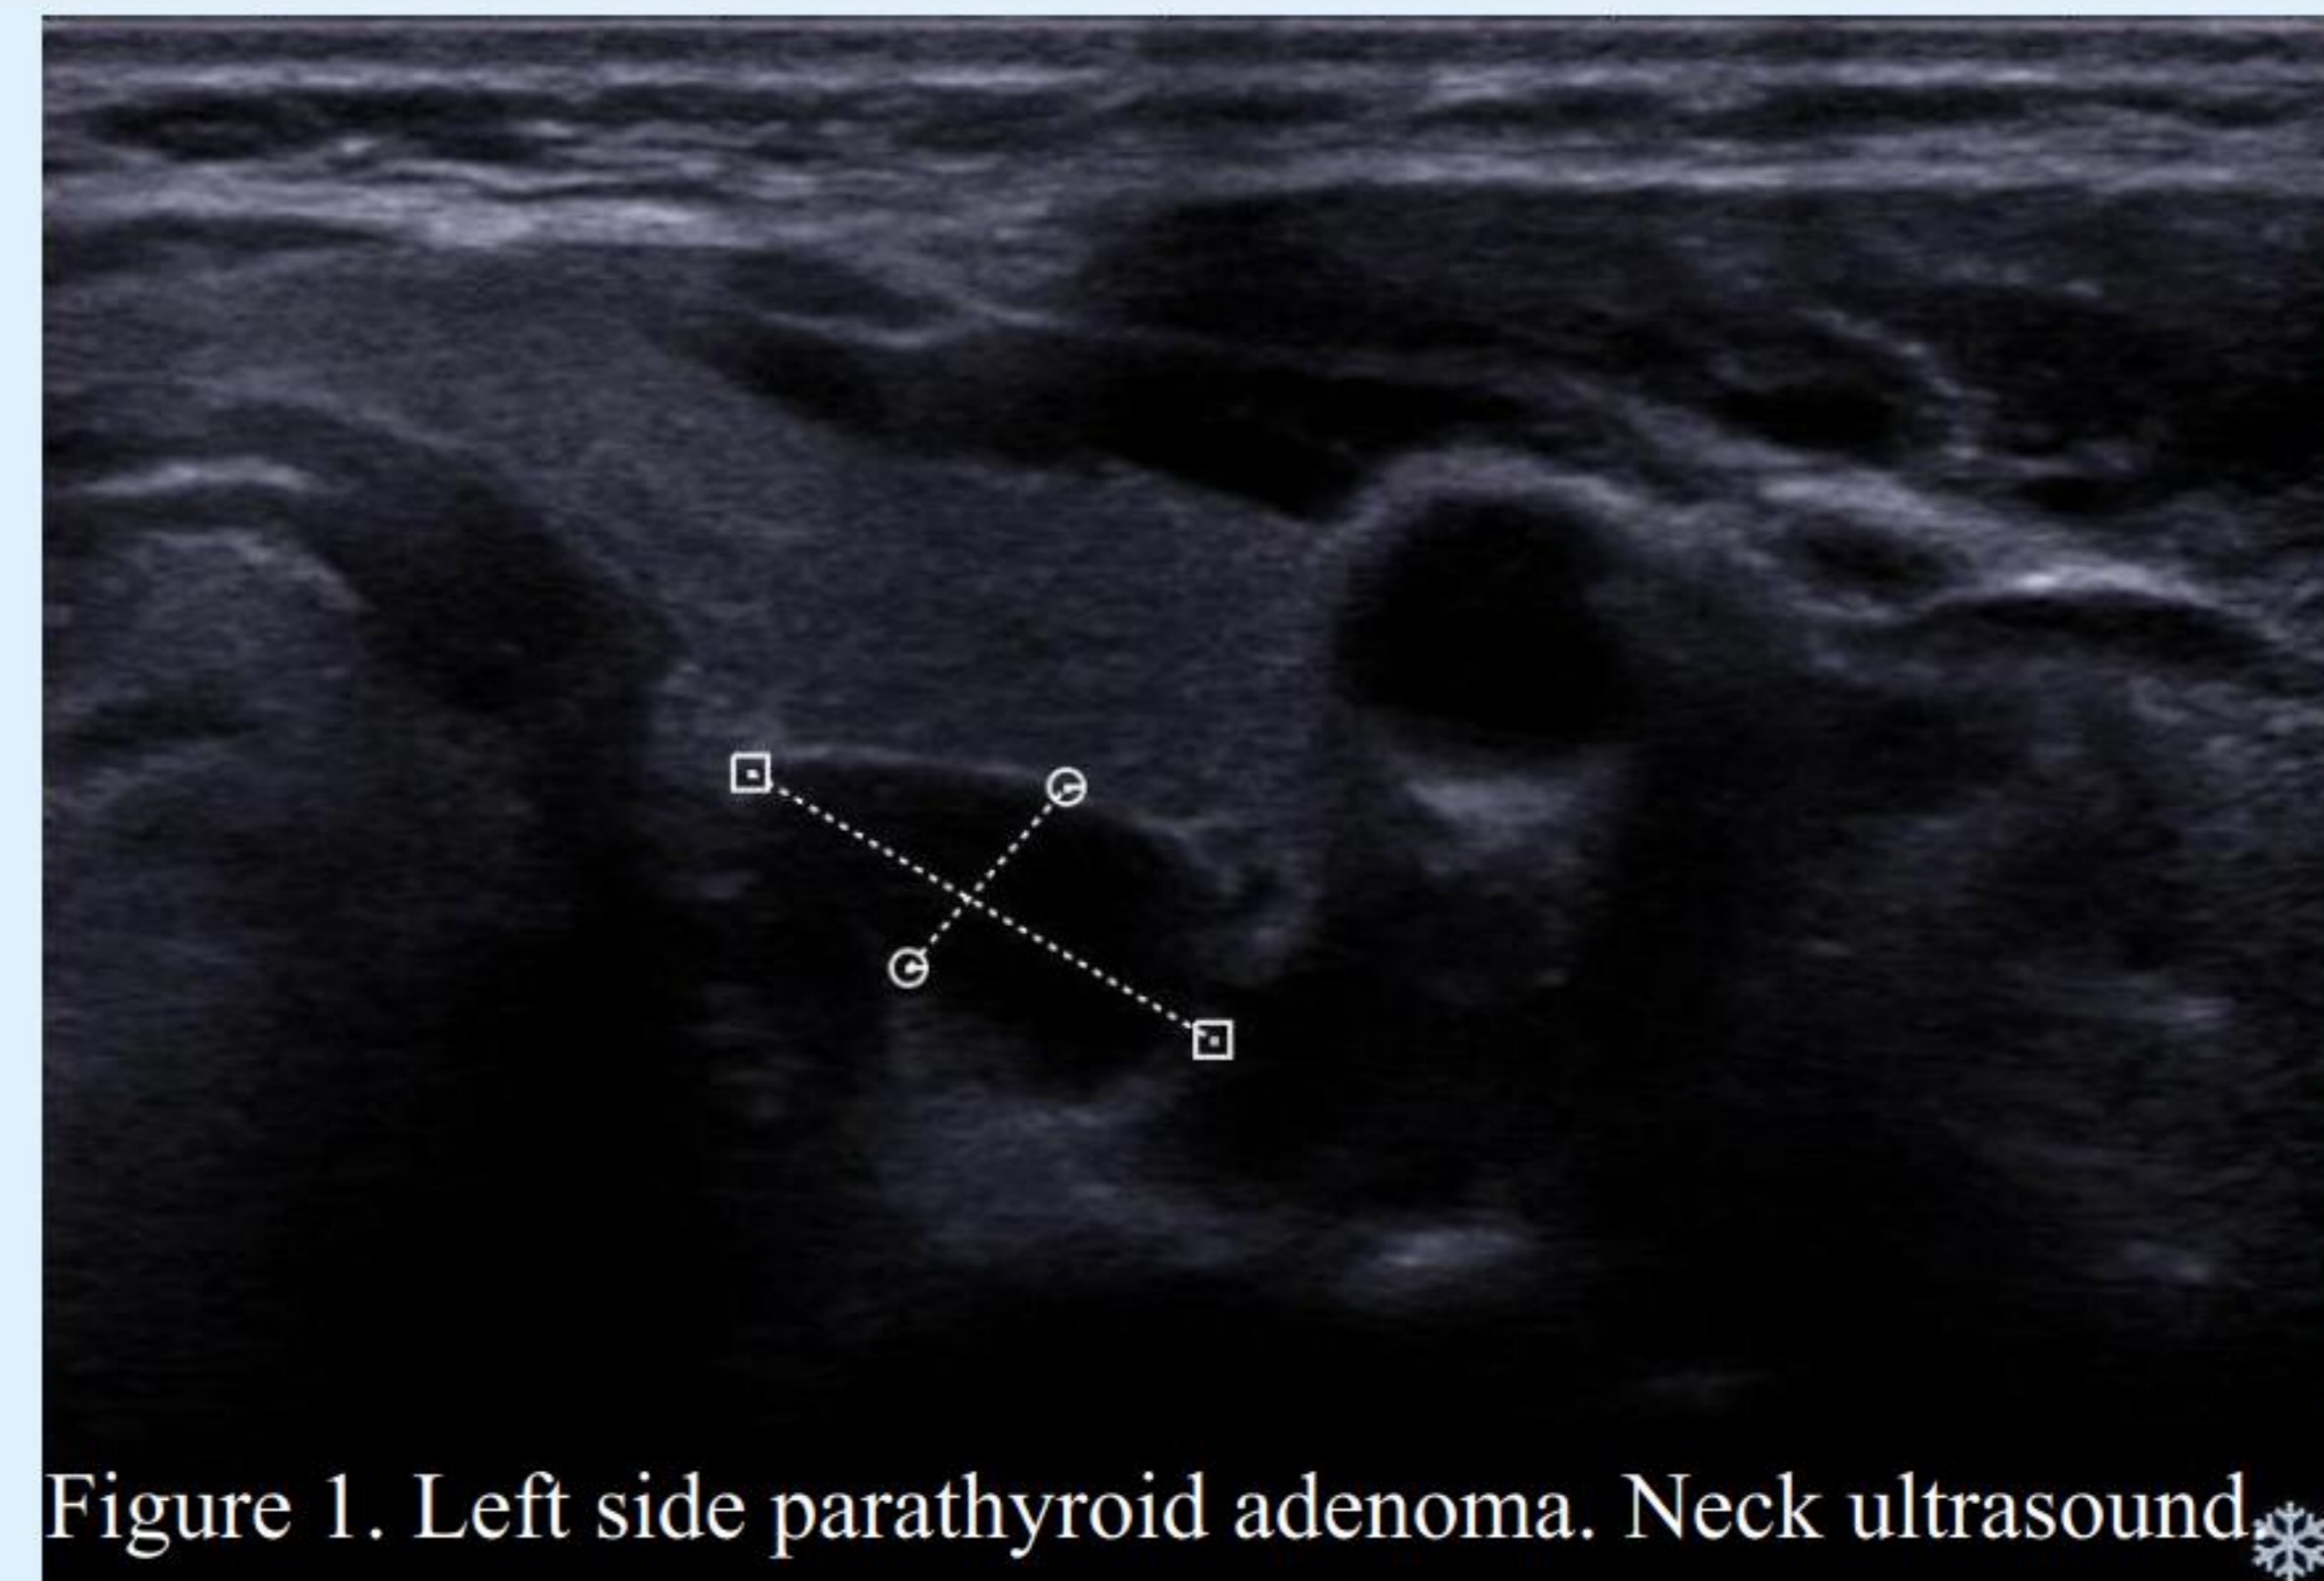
Left side parathyroid adenoma. Neck ultrasound.
